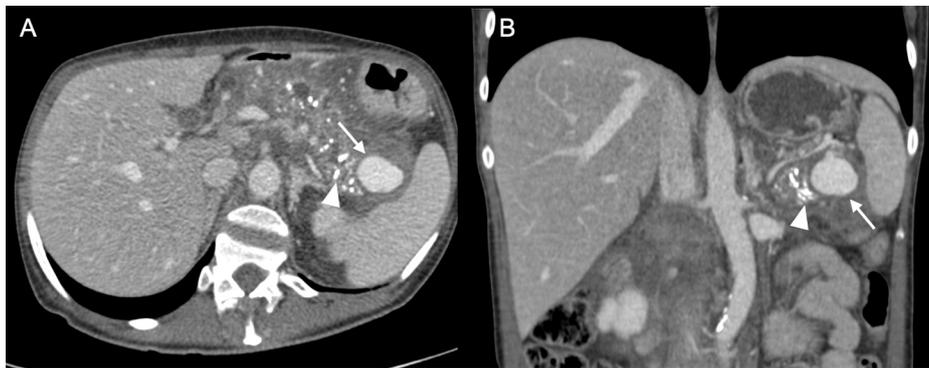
A 50-year-old man with a previous history of chronic pancreatitis had an episode of exacerbation. Axial (A) and coronal (B) CT angiography reconstructions of the abdomen and pelvis in the arterial phase show a pseudoaneurysm of the splenic artery (arrow) adjacent to the tail of the pancreas and close to the splenic hilum. The pancreas shows numerous calcifications (arrowhead) as a sign of chronic pancreatitis.
